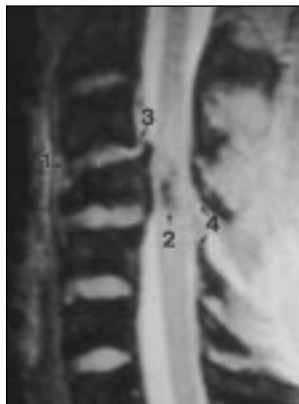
Burst fracture of C4 with retropulsion in 17-year-old boy after motor vehicle crash. Sagittal gradient-echo MR image (TR/TE, 650/13; flip angle, 15°) obtained on 1.5-T MR scanner shows anterior longitudinal ligament tear (1), hypointense hemorrhagic cord contusion (2), posterior longitudinal ligament tear at C3-4 (3), and flaval ligament tear at C4-5 (4).
